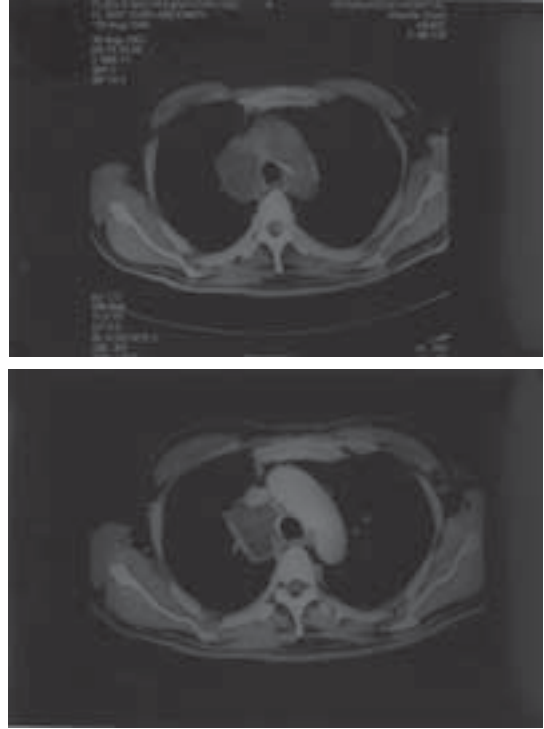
Computed tomographic (CT) scan revealed a soft tissue density mass 3.9 x 4.8 cm at the right tracheobronchial region, likely an intrapulmonary mass.
